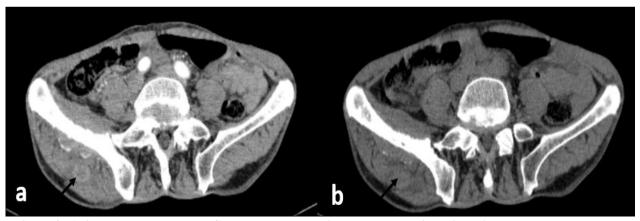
Axial contrast-enhanced CT scan demonstrating a nodular lesion with mild contrast enhancement located within the right gluteus maximus muscle (black arrows)
